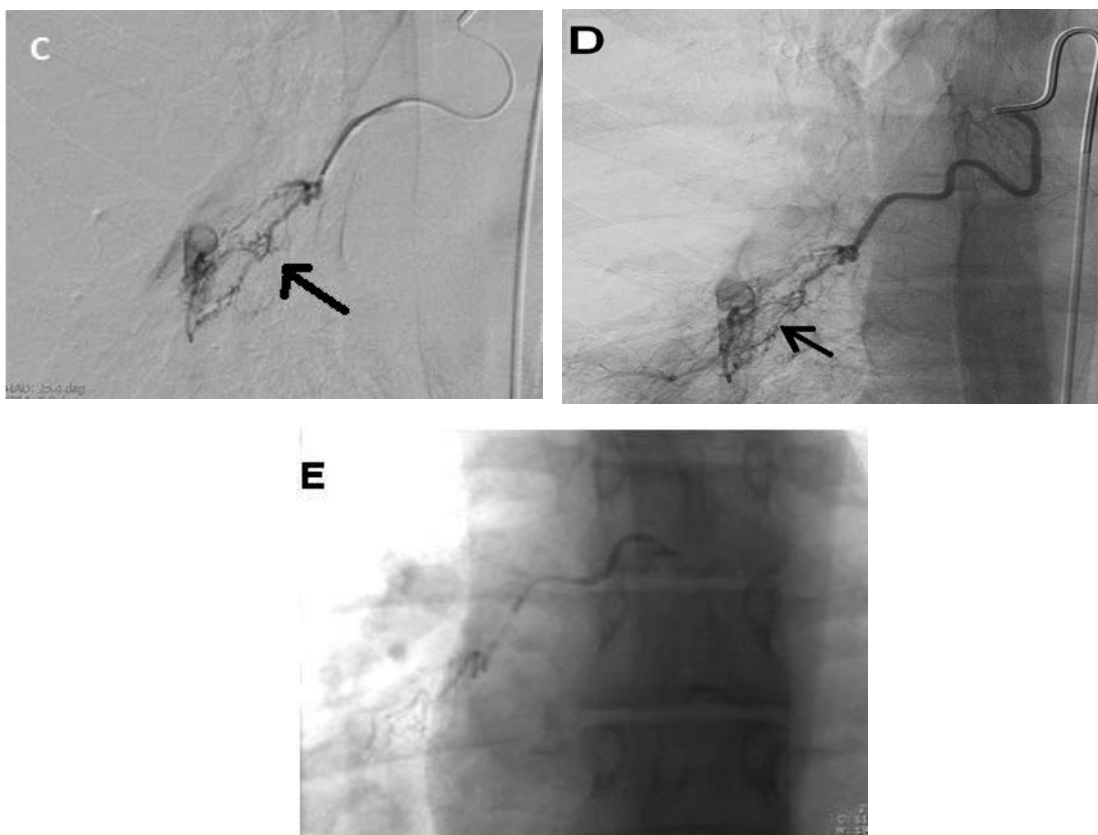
A: CT angiography of the thorax: Peribronchial thickening in the lower zone of the right lung.
